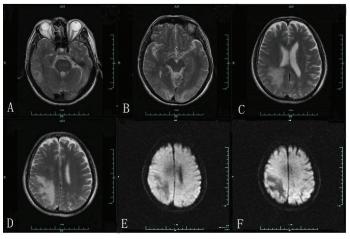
A–D: T2-weighted magnetic resonance imaging (MRI) showing hyperintense signal in the right temporal, both occipital and right occipital-parietal lobe; E–F: diffusion weighted imaging (DWI) showing hypointense lesion in the right occipital-parietal lobe.
